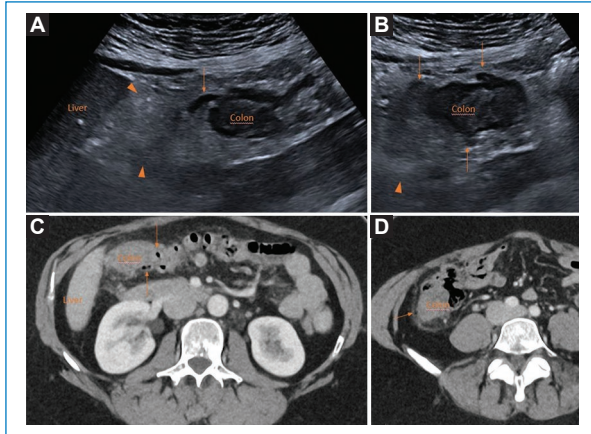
A 44-year-old female who presents to the emergency department because for 3 days she has had pain at the level of the right hemiabdomen more localized in the RIF with chills without measured fever. She was assessed 24 hours prior in the emergency department, for the same reason without analytical alterations and with response to analgesia. She currently has pain that does not subside with analgesia, elevated leukocytosis and C-reactive protein. On examination, pain in the RIF and right flank that increases with decompression. Ultrasound is requested to rule out appendicitis. A and B: ultrasound centered on the right hemiabdomen, showing multiple diverticula with inflammatory changes (thin arrows), thickening of the ascending colon wall and marked hyperechogenicity of the adjacent pericolic fat (arrowheads). As this is an extensive right-sided diverticulitis, complementary abdominal CT with contrast in venous phase is performed. C and D: axial CT slices centered on the ascending colon. Extensive right-sided diverticulitis is confirmed (thin arrows) without signs of complication. The patient is admitted with antibiotic treatment and intravenous analgesia with favorable evolution. RIF: right iliac fossa; CT: computed tomography.
